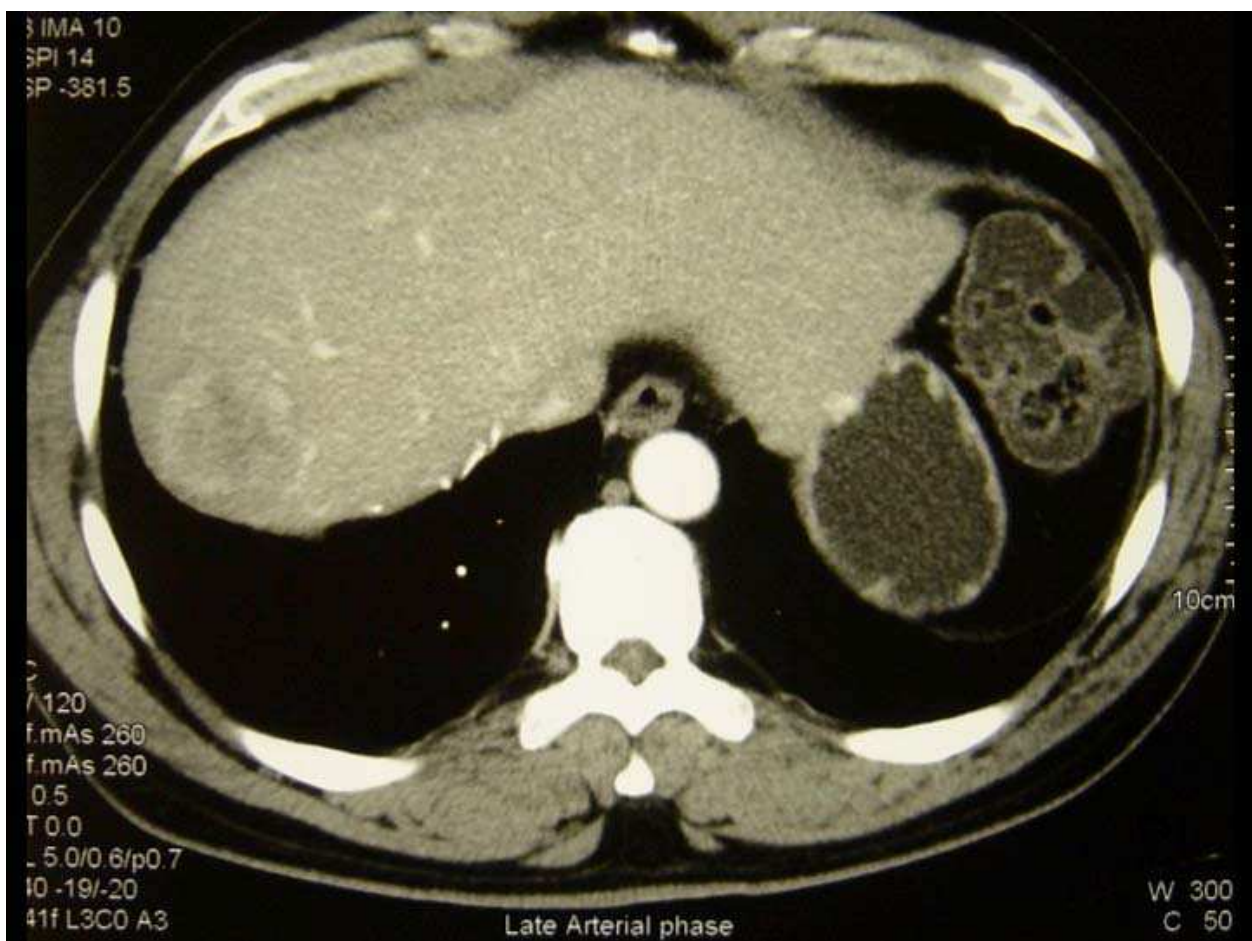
Pre-operative CT image of a recurrent HCC at segment VIII of liver.
